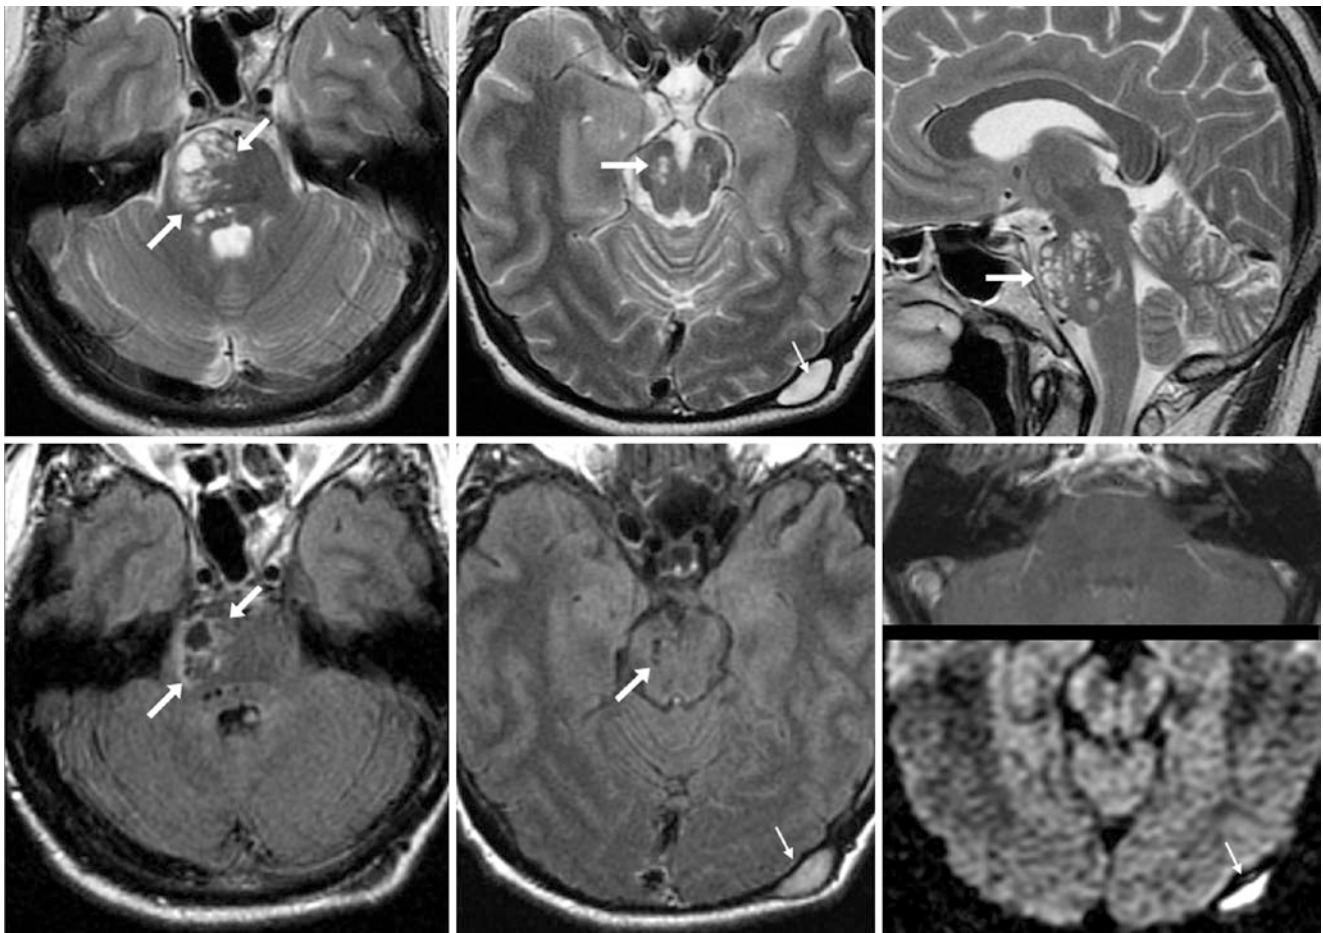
Tumefactive (giant) dilated PVs. A 38 year old had mild, chronic headaches and a reportedly stable brainstem lesion (*arrows*) for 11 years (*old images were not available*). The PVs are multiloculated, with CSF intensity on axial (*top left*) and coronal (*top right*) T2WIs and suppression of the majority of the spaces on FLAIR images (*bottom*
